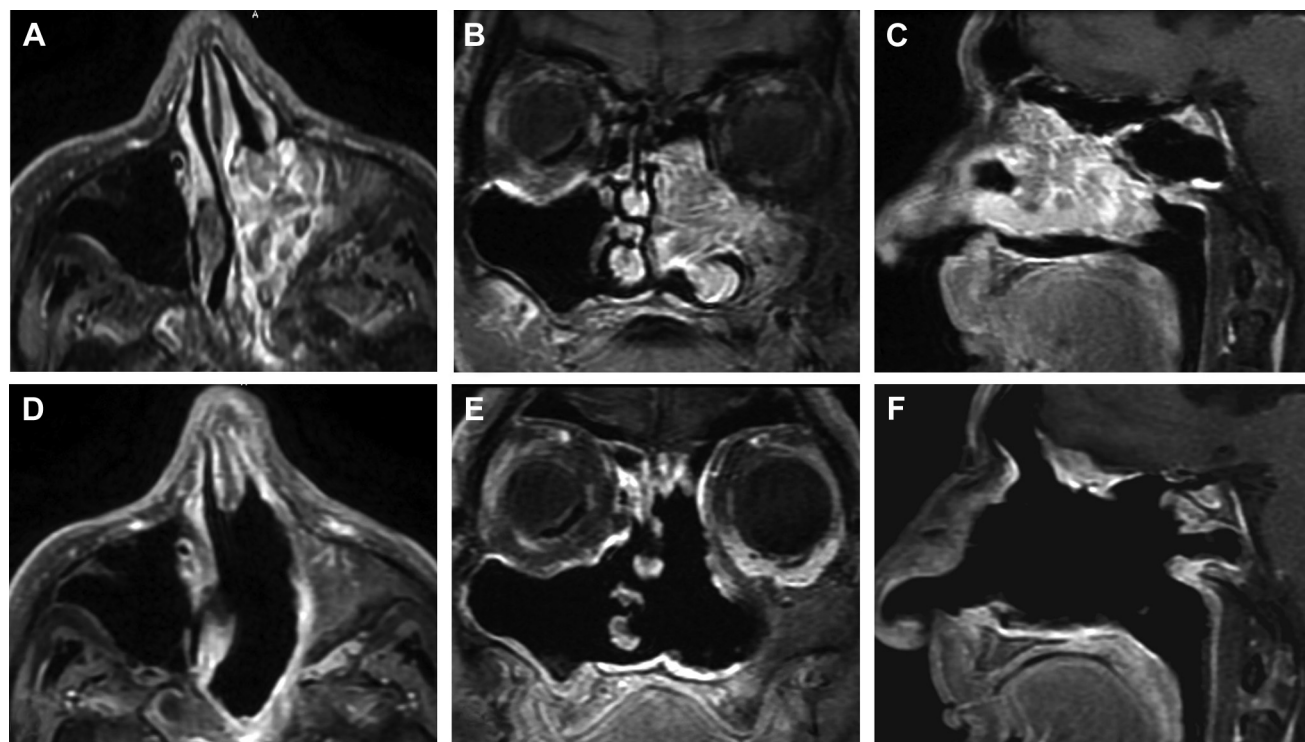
Exclusively endoscopic endonasal resection of left maxillary squamous cell carcinoma, arising from inverted papilloma (stage T1N0M0). Preoperative and postoperative contrast-enhanced T1-weighted magnetic
